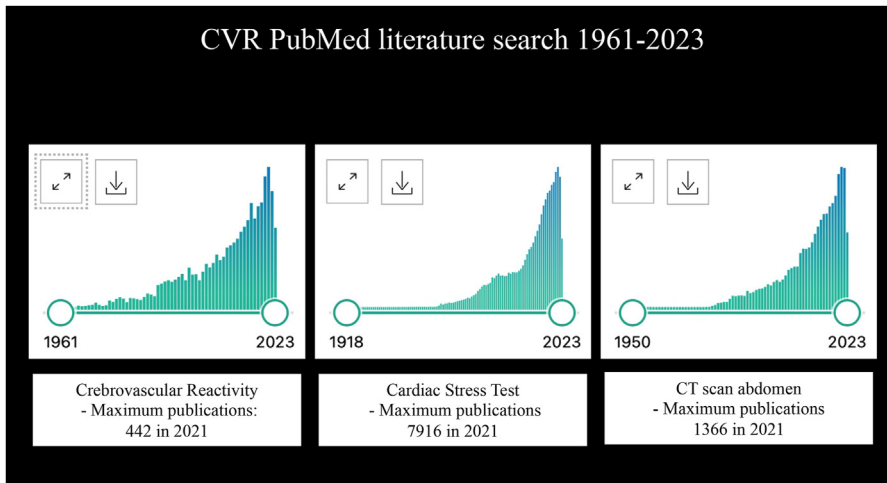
PubMed literature search using search terms “Cerebrovascular Reactivity,” “Cardiac Stress Test,” and “CT Acan Abdomen.”
